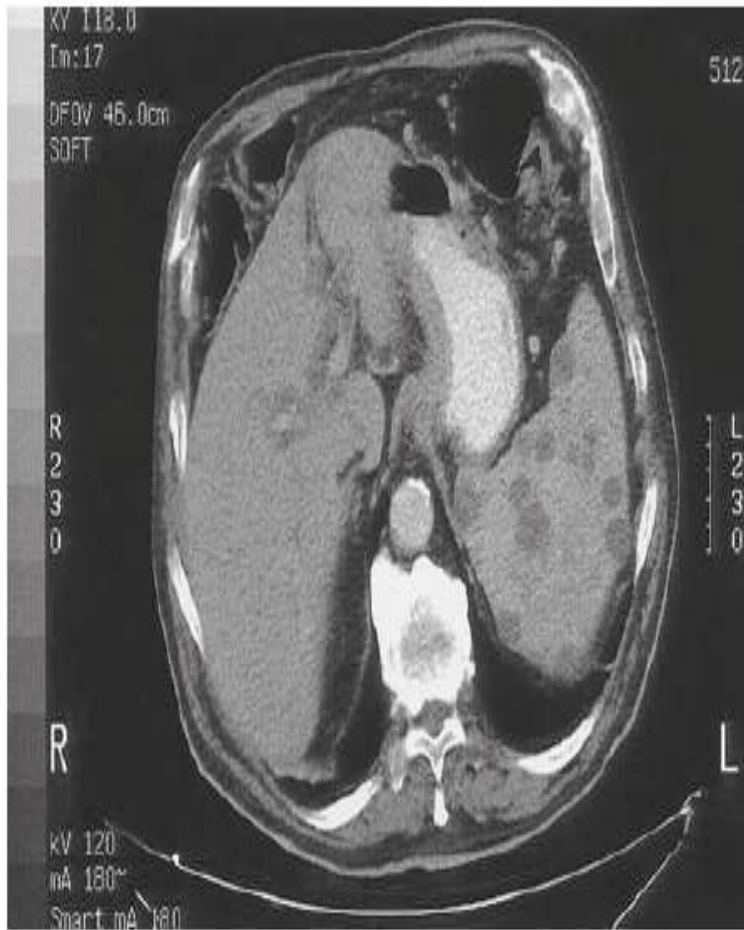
Computed tomography scan showing multiple low-density areas in the spleen consistent with multiple benign splenic cysts.
